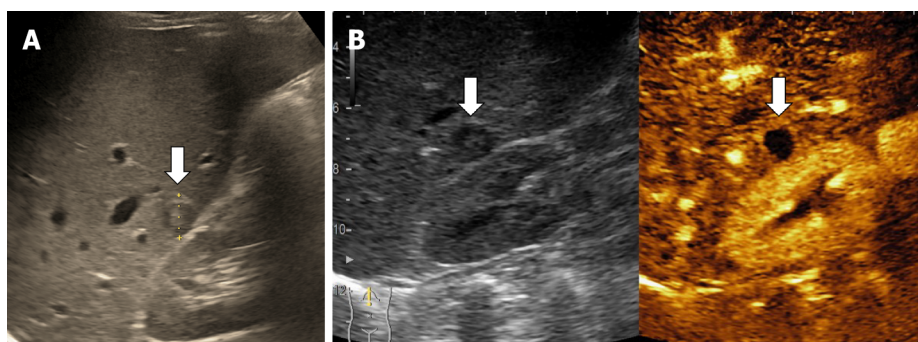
Sclerosed hemangioma in a 45-yr-old man detected on a routine ultrasound examination. A: B-mode ultrasound revealed a small hypoechoic lesion; B: In contrast enhanced ultrasound no enhancement is observed.
